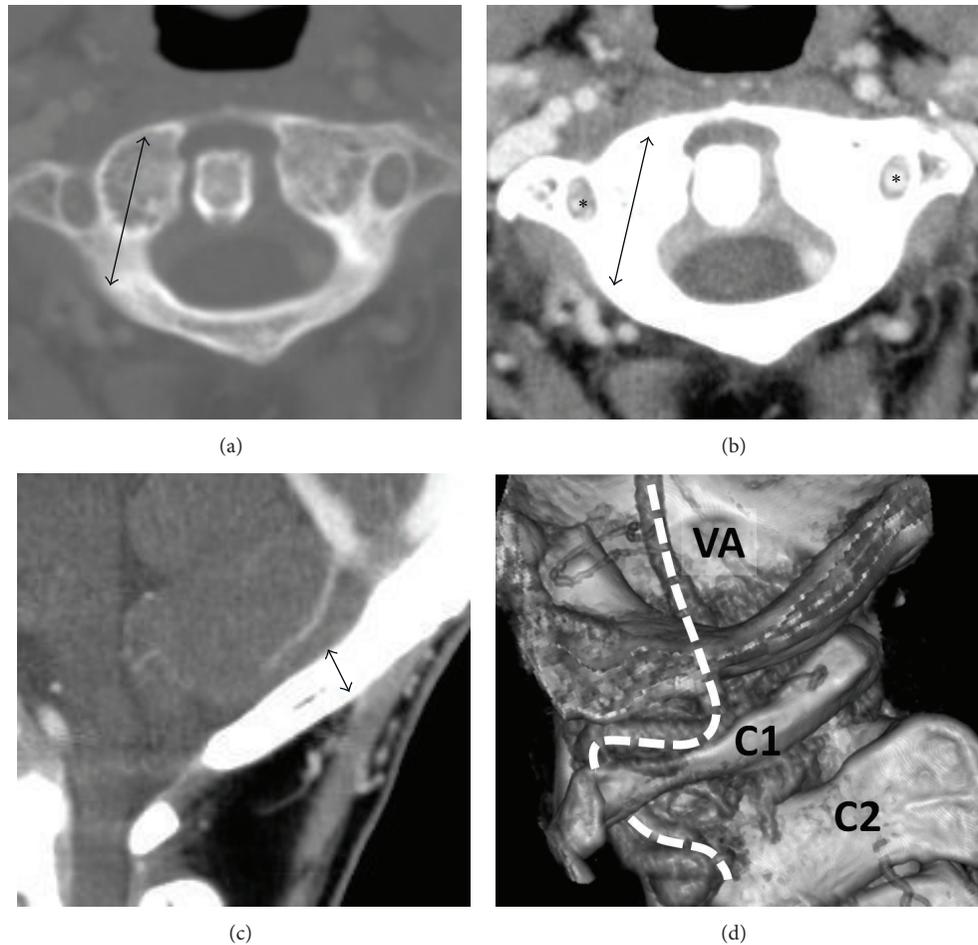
Preop reconstructive computed tomography for choosing pedicle screw length and diameter (a), knowing the screw and vertebral artery relationship (*asterisk*) (b), choosing occiput screw length (c), and the vertebral artery (*dashed line*) direction (d).
